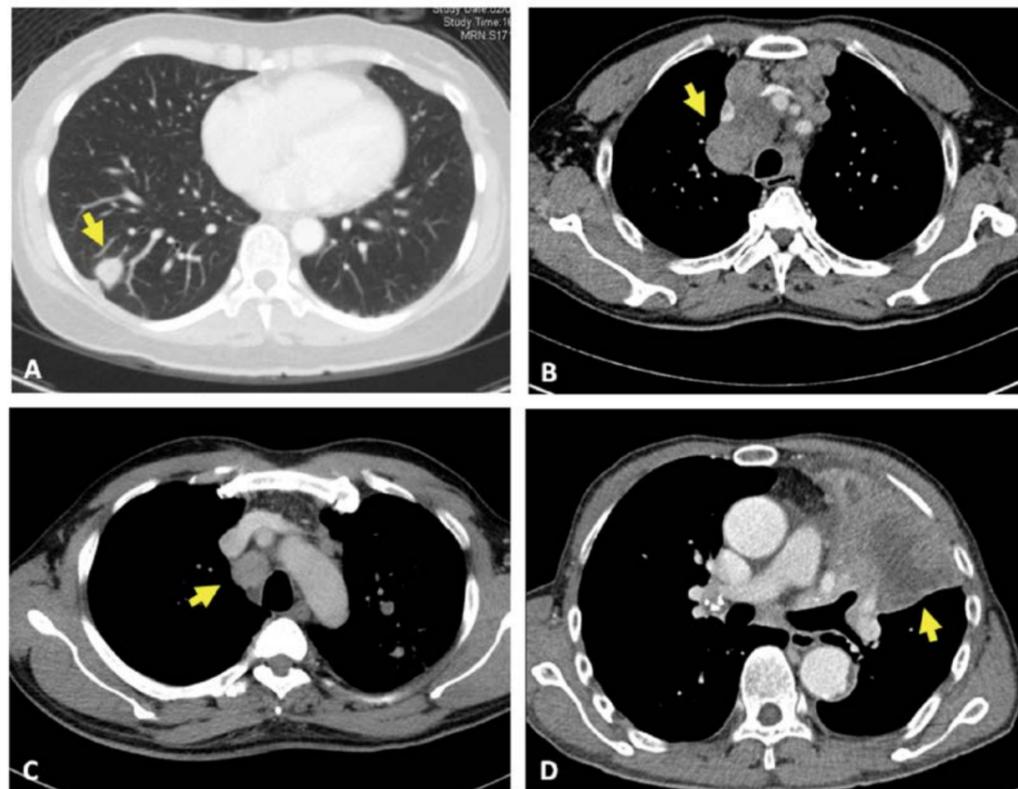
Common radiological patterns of lung cancer on CT scan. A: peripheral nodule or mass; B: discrete mediastinal lymph node; C: mediastinal infiltration; and D: endobronchial lesion with distal lung atelectasis.
